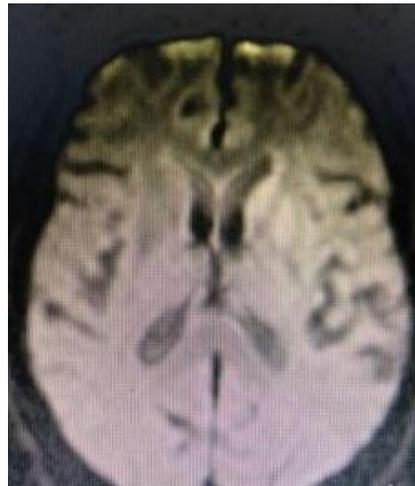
MRI of patient showing signs of infarct was seen in left middle cerebral artery territory and basal ganglia in left hemisphere
